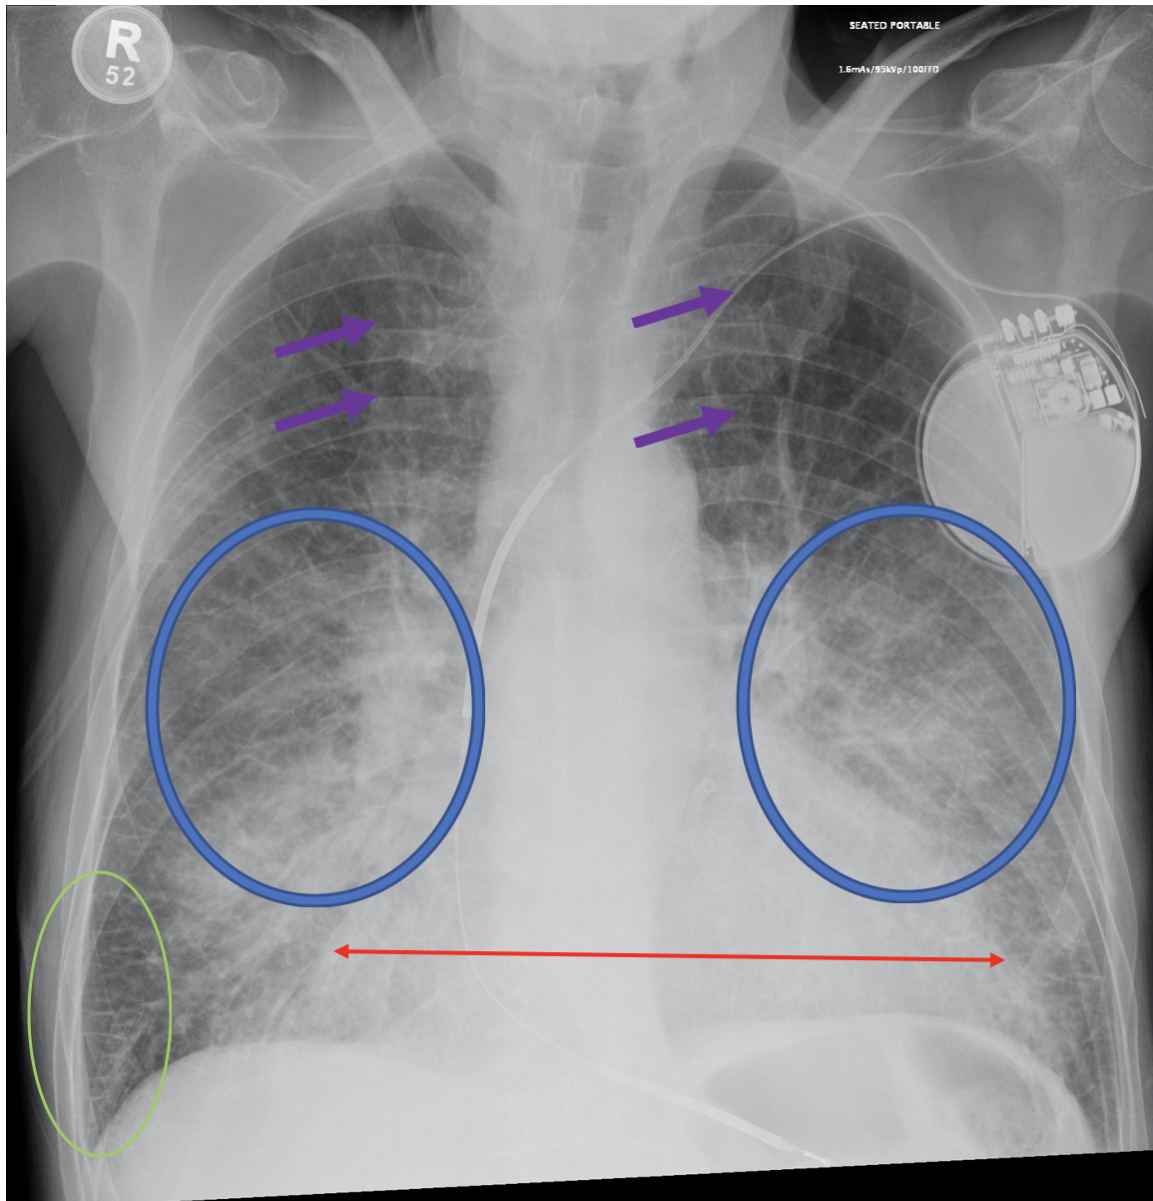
Annotated Chest X-Ray demonstrating signs of Pulmonary Edema. Chest X-Ray of a 60 year-old male who presented with shortness of breath. Note the pacemaker in the left hemithorax.
